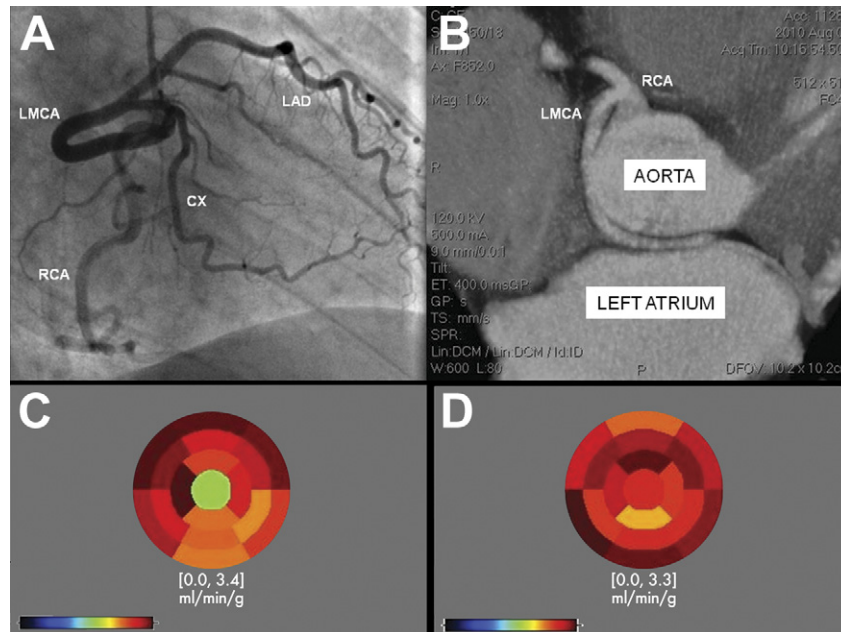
Coronary angiography, computed tomography coronary angiography and positron emission tomography images. (A) Coronary angiogram showing a right anterior oblique projection. The course of the LMCA appeared to be retroaortic, and this was subsequently confirmed by (B) computed tomography coronary angiography: maximum intensity projection image with increased slab thickness. Computed tomography also disclosed several other interesting elements: normal origin of the RCA from the right sinus of Valsalva, LMCA with a regular ostium and tight-angle takeoff from the proximal RCA, absence of coronary atherosclerosis. (C) Positron emission tomography scan before surgical correction, showing dipyridamole myocardial blood flow to be reduced in the apical segment of the left ventricle (1.86 mL/min/g compared with a mean value of 2.92 mL/min/g [range, 2.47 to 3.35 mL/min/g] in the remaining segments). (D) Return to normal after surgical correction (2.75 mL/min/g compared with a mean value of 2.89 mL/min/g [range, 2.33 to 3.26 mL/min/g] in the remaining segments). (CX = circumflex artery; LAD = left anterior descending artery; LMCA = left main coronary artery; RCA = right coronary artery.)
